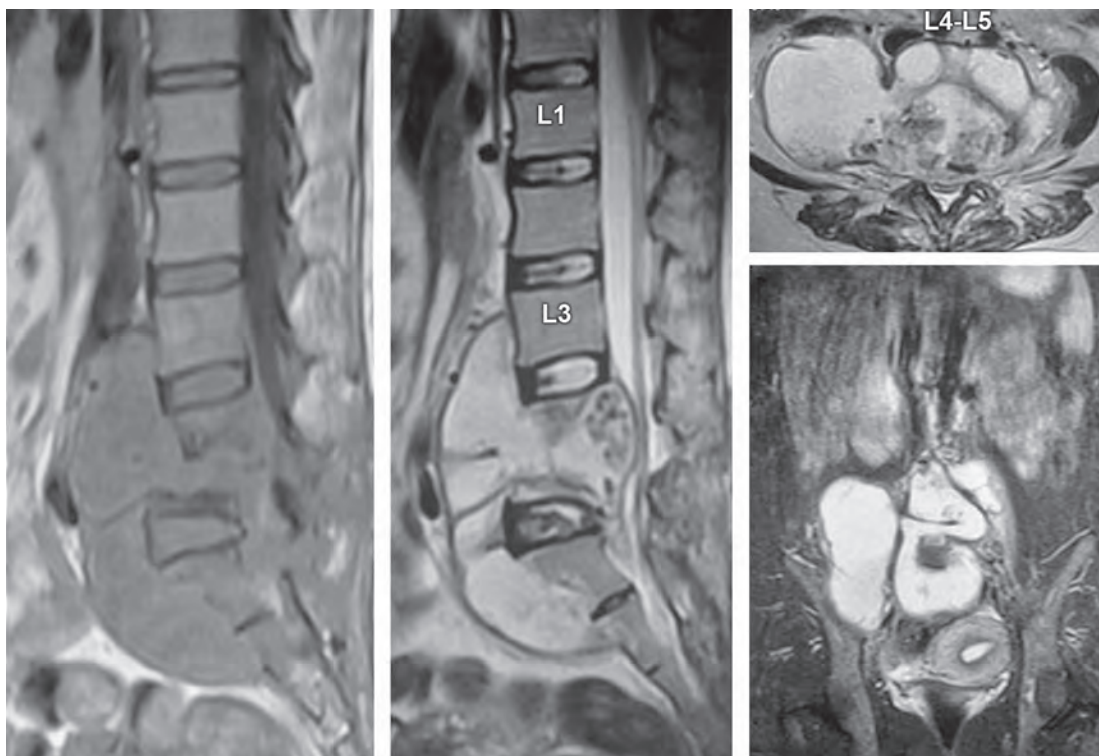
MRI of a patient with lumbosacral caries showing significant pre- and paravertebral cold abscess along with compression of the thecal sac and the exiting nerve roots
